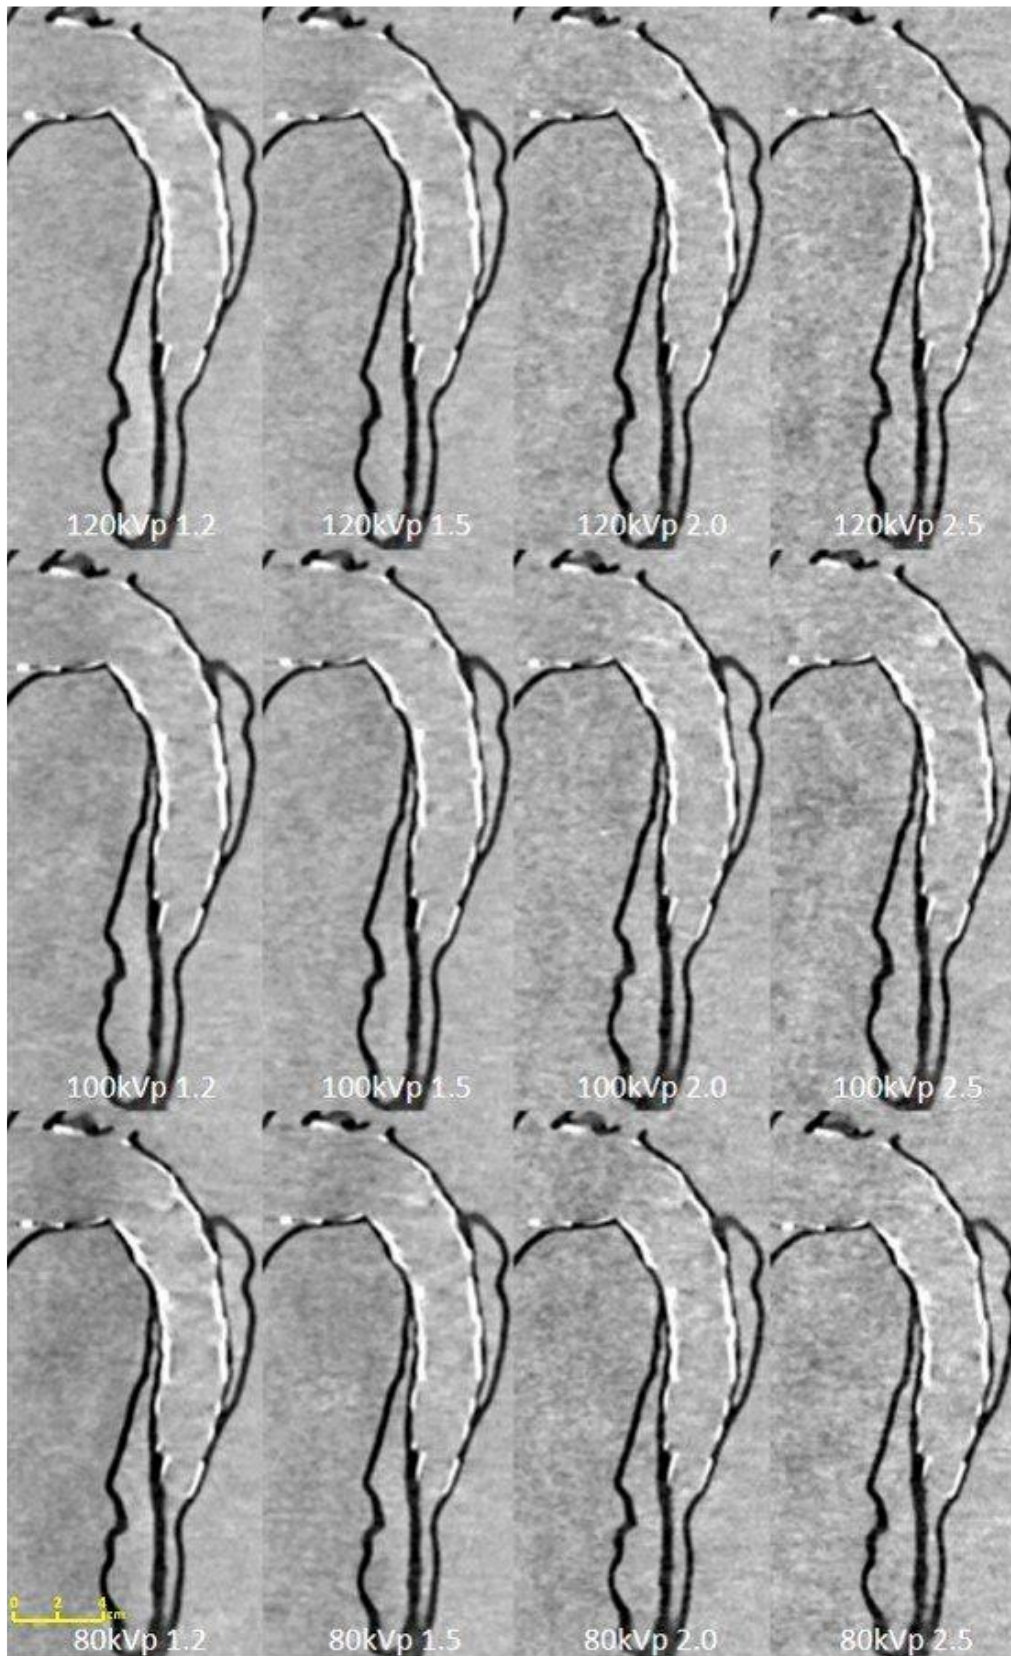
Sagittal reformatted images of the CTA protocols. When kVp decreased to 80, image noise increased with the use of high pitch value protocols such as 2.0 and 2.5. CTA: computed tomography angiography, kVp: kilovoltage peak.
